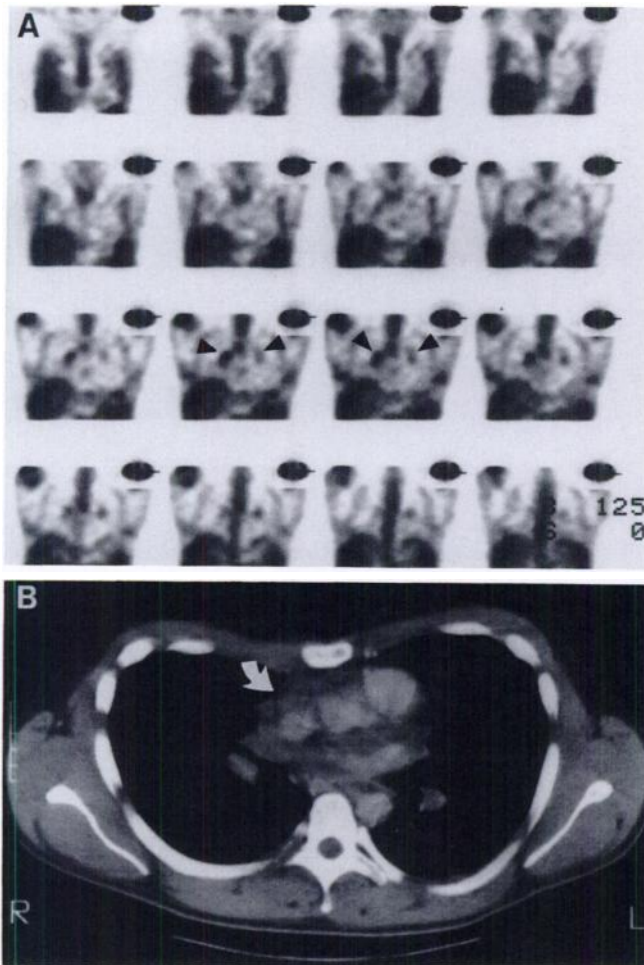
(A) A 36-yr-old male with mediastinal Hodgkin's disease treated with chemotherapy, which was completed 2 mo prior to imaging. SPECT images depict increased radiotracer uptake in both hilar regions (arrows), compatible with residual disease. Irregular lung uptake, attributable to chemotherapy, is also visible. (B) CT scan on the same patient demonstrates a subtle focus of residual mass in the right anterior mediastinum (arrow) indiscernible from active disease and interpreted as consistent with either fibrosis or residual mass, whereas biopsy of a right hilar lymph node revealed nodular sclerosing Hodgkin's disease.
